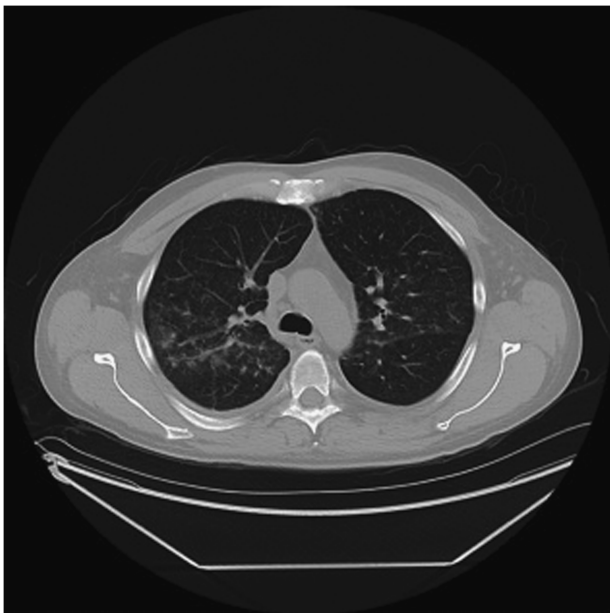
CT of the chest. An area of limited pulmonary hemorrhage is observed in the right middle and upper lung zones.
